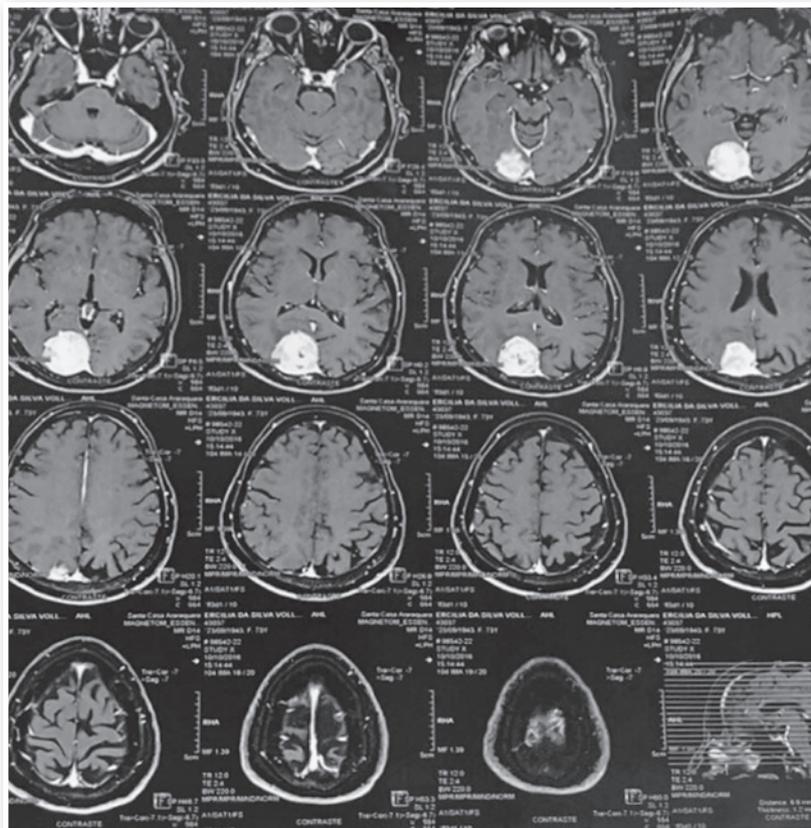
Nuclear magnetic resonance imaging.
